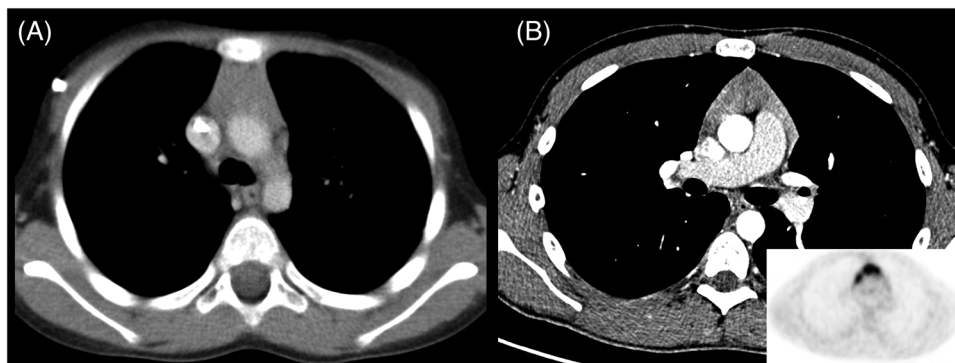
Rhomboid (A) and triangular (B) shapes both with homogeneous parenchyma without any mass effects in computed tomography (CT) appearance, less concerning for malignancy, of (A) rebound thymic hyperplasia (RTH) in a 4-year-old male patient but (B) thymic lymphoma relapse (LR) in a 15-year-old male patient. The corresponding PET in the lower right corner shows multifocal uptake.
